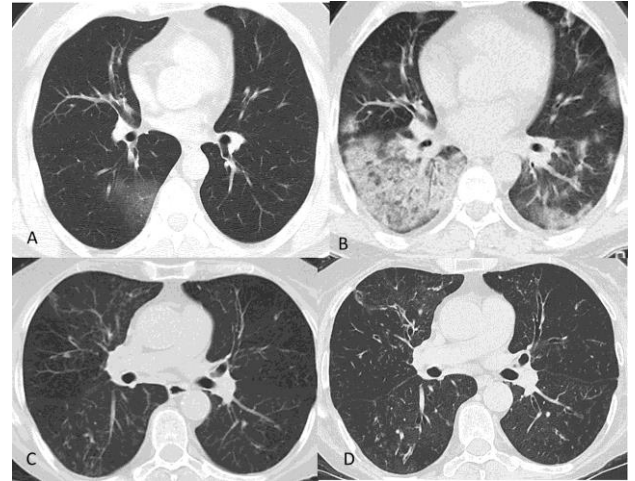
A 41-year-old male patient who presented with fever had a subpleural GGO density on the chest CT performed 1 day after the onset of symptoms (A). The CT of the same patient performed after 8 days showed diffuse consolidation and GGOs in both lungs, more significantly in the right lower lobe (B). A 71-year-old female patient who presented with fever and joint pain had peribronchovascular GGOs density in both lungs and bronchiectasis in the upper lobe of the left lung on the chest CT performed 3 days after the onset of symptoms (C). While the CT of the same patient performed 8 days after the first CT showed no significant difference in the GGOs density in both lungs, and there was an increase in the bronchiectatic changes in both lungs, more significantly in the right lung (D).
